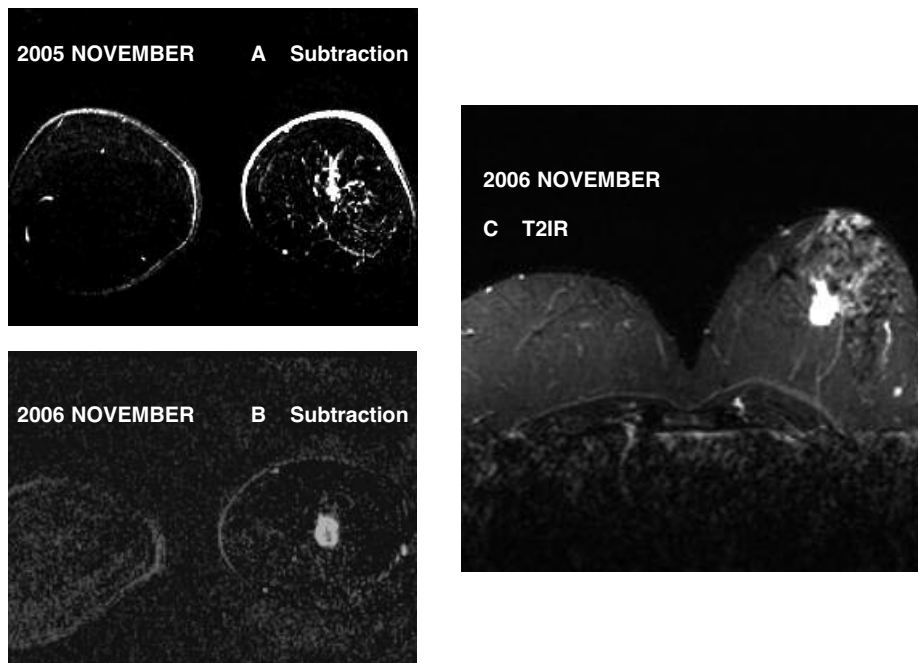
Patient no. 24. A) Subtraction imaging of November 2005; B) subtraction imaging at the recall; C) T2 IR. Fifty-four years old, BRCA1 mutated, already submitted to breast resection of the right breast. A suspected dendritic enhancement was seen in the left parenchyma at MRI (A). Neither mammography nor ultrasound revealed any abnormal finding. The mammographic pattern was P2. The patient had already been enrolled in our diagnostic surveillance program for one year, and previous MRI was completely negative with uniform darkness of both parenchyma on subtracted images. The patient refused MRI follow-up because of claustrophobia. One year later, previous enhancement was frankly increased, had converted into a mass-like morphologic pattern with irregular margins with rim enhancement (B). Also in this case, the brightness of T2 SI was impressive (C). Mammography and ultrasound were still negative. The lesion corresponded to an invasive ductal carcinoma.
